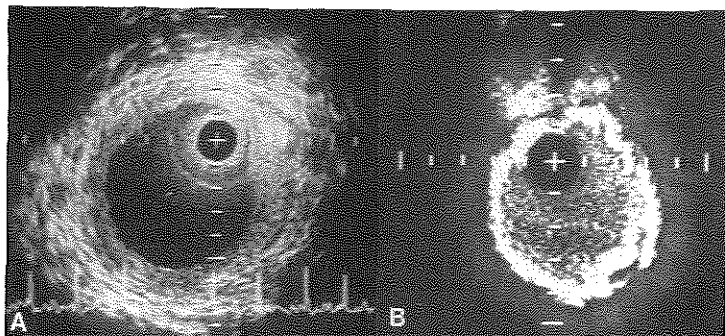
Intravascular ultrasound cross sections obtained from two patients without the normal three-layered appearance of the superficial femoral artery wall. Panel A: A homogeneous arterial wall is seen. Panel B: A bright homogeneous arterial wall presumably represents a circumferential calcific plaque. Note echogenicity of blood inside the lumen. Calibration = 1 mm.
